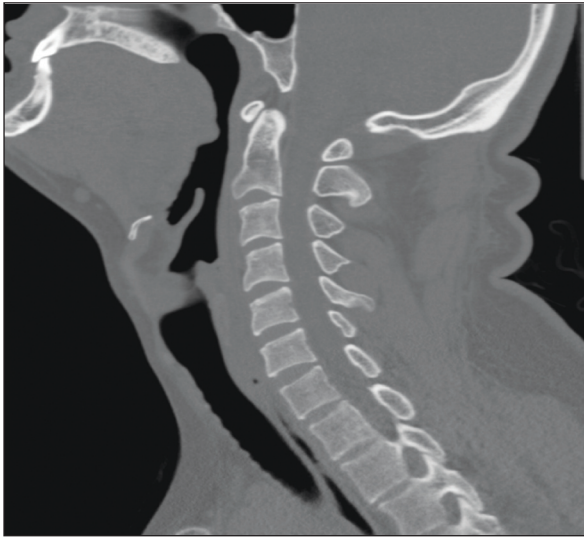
Normal cervical computed tomography image
